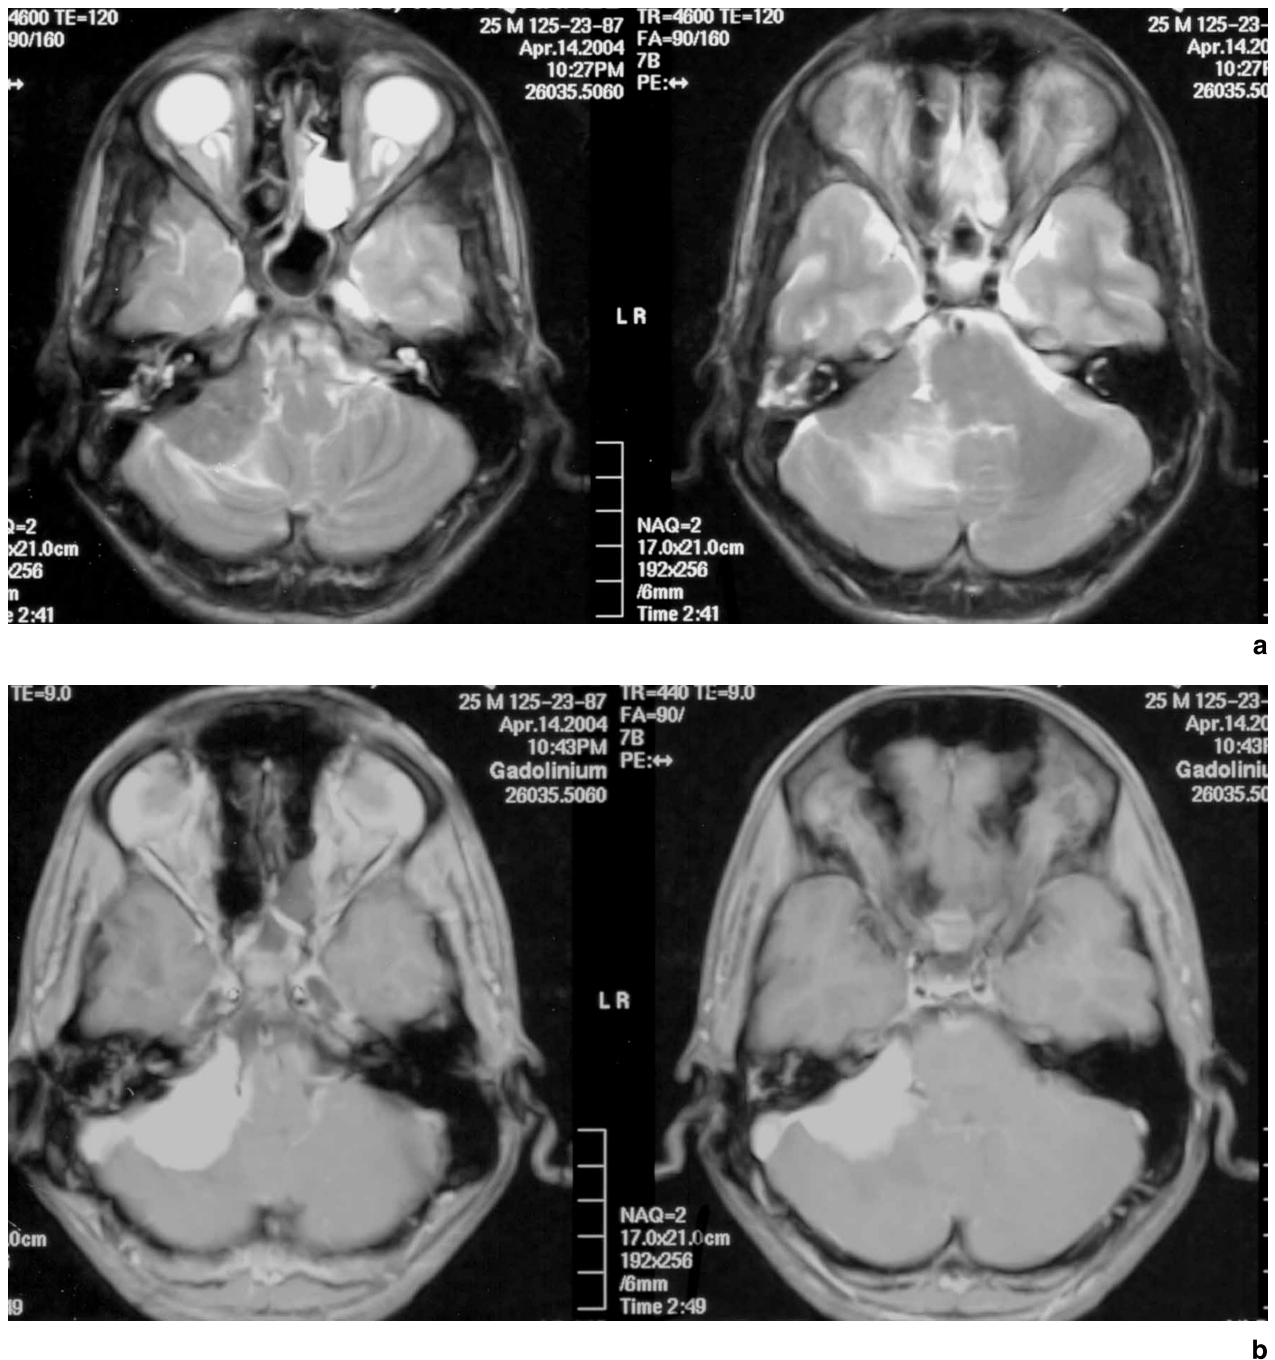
(a) T-2 weighted MR imaging (axial sections) showing a mass lesion in the right cerebellopontine angle with broad base on the petrous bone. It is producing hypo-to-iso-intense signals with no peri-focal edema. (b and c) Post-contrast imaging (axial and coronal sections) with T-1 weighted sequence producing bright homogenous enhancement of the same mass lesion. There is associated dural enhancement and slight displacement of brain stem
